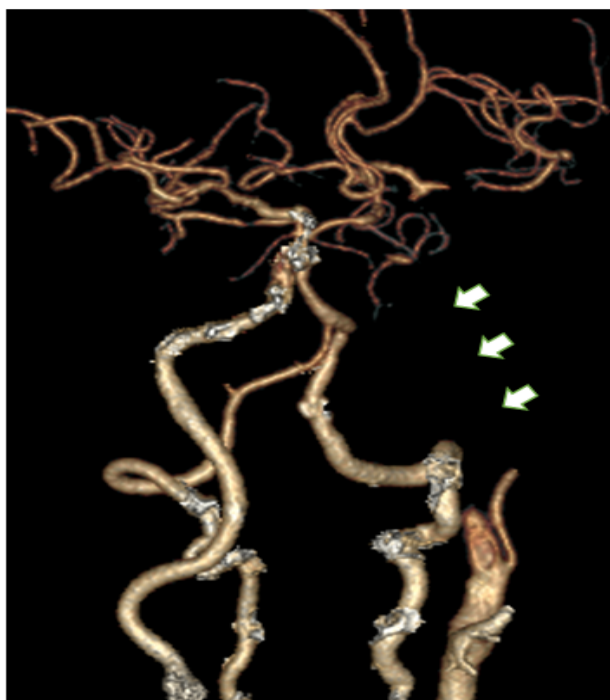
Brain CTA demonstrated acute total occlusion of left ICA from proximal segment (white arrows).
